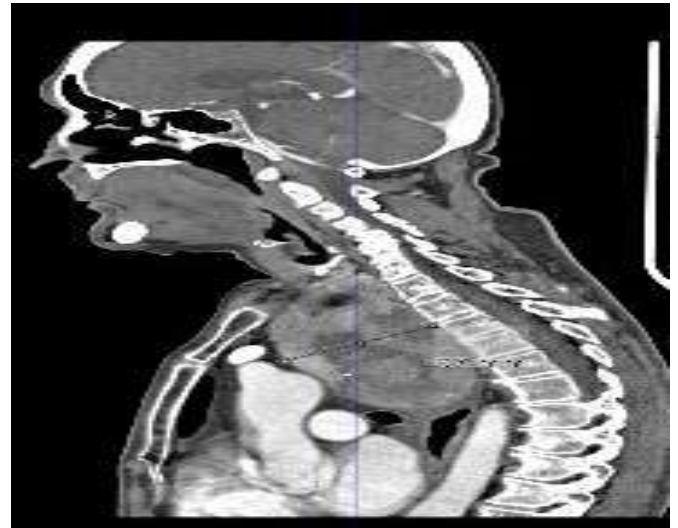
Preoperative coronal CT scan.
